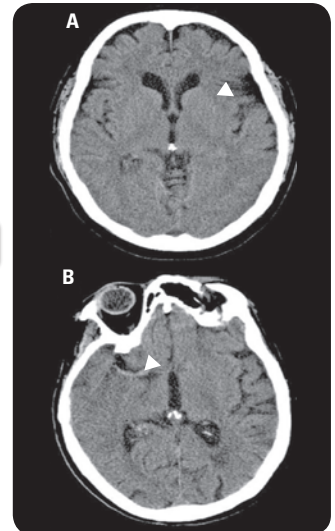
CT images of early infarct: (A) absence of left insular ribbon (B) hyperdense artery
